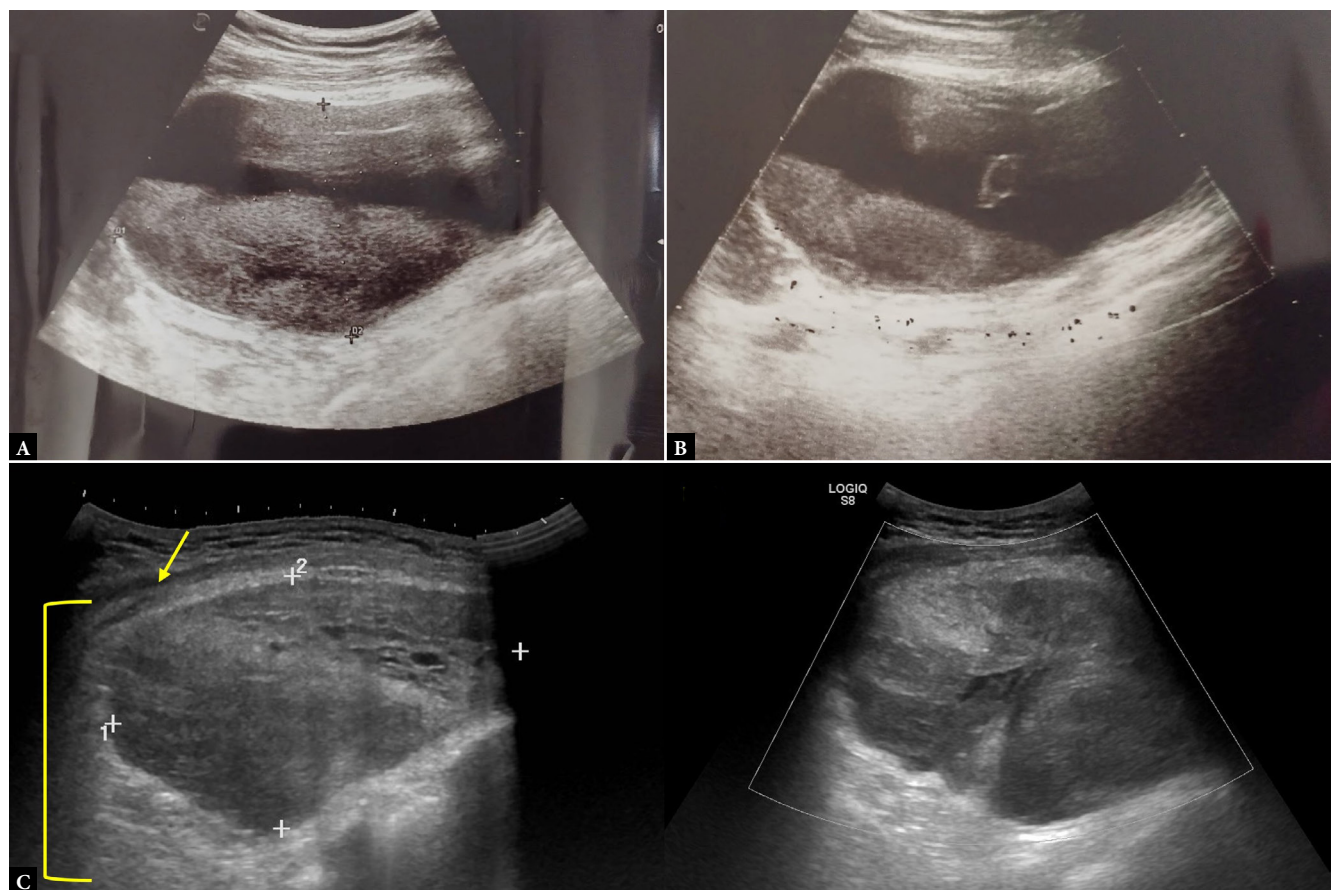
Ultrasound of the right pectoral region showing a large heterogeneous subfascial (yellow arrow) intramuscular (yellow bracket) collection (12 × 6 × 12 cm) without internal vascularity on CD, consistent with a subacute iatrogenic hematoma (A, B, C). Follow-up US performed one week later (D) demonstrates increased disorganization, internal echogenic strands, and persistent absence of vascular signal, confirming hematoma evolution
